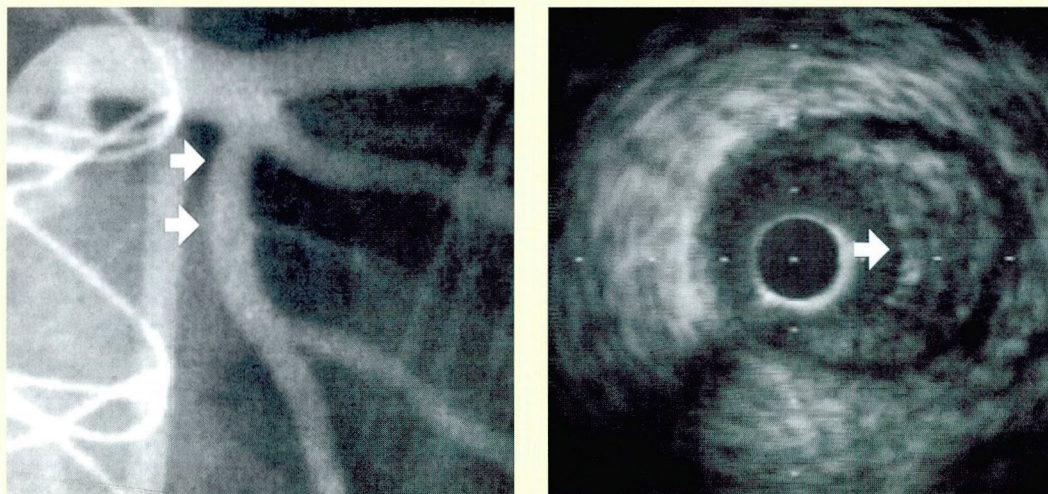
Vessels can change their shape to accommodate an atheroma. Left, angiography shows apparently stenosis-free proximal left circumflex artery (arrows). Right, intravascular ultrasonography on the same segment reveals the presence of a large, crescent-shaped atheroma that occupies about 50% of the luminal area. Angiography could not detect the lesion because the adventitia had remodeled outward, which allowed the lumen to remain circular and to maintain the same size as the adjacent uninvolved segment.
